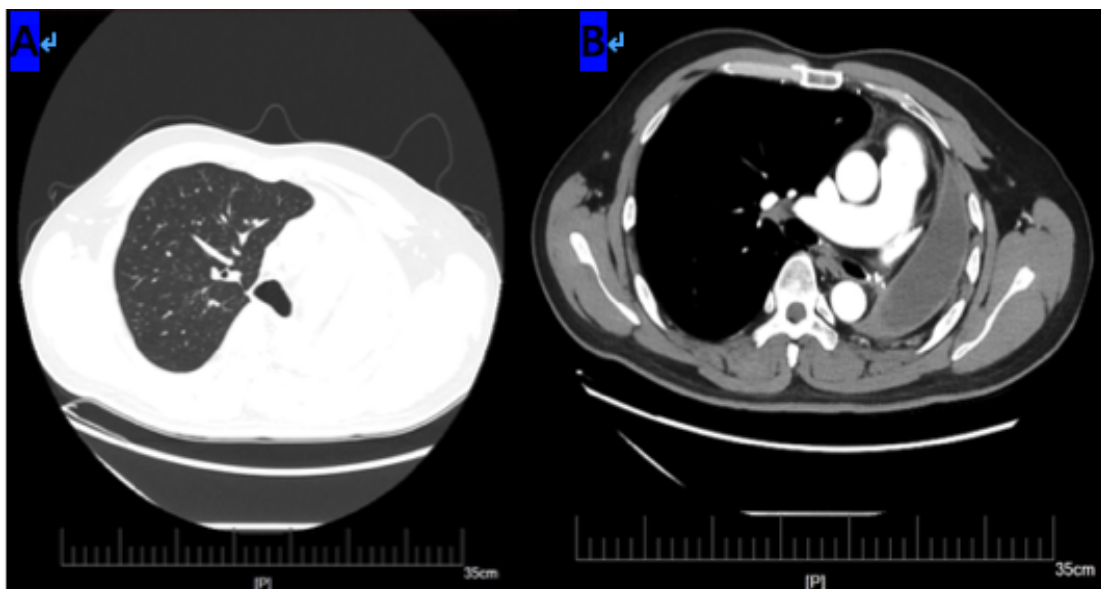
(A) The Chest CT image after thoracoscopic lobectomy. (A) Lung window; (B) Mediastinal window.
